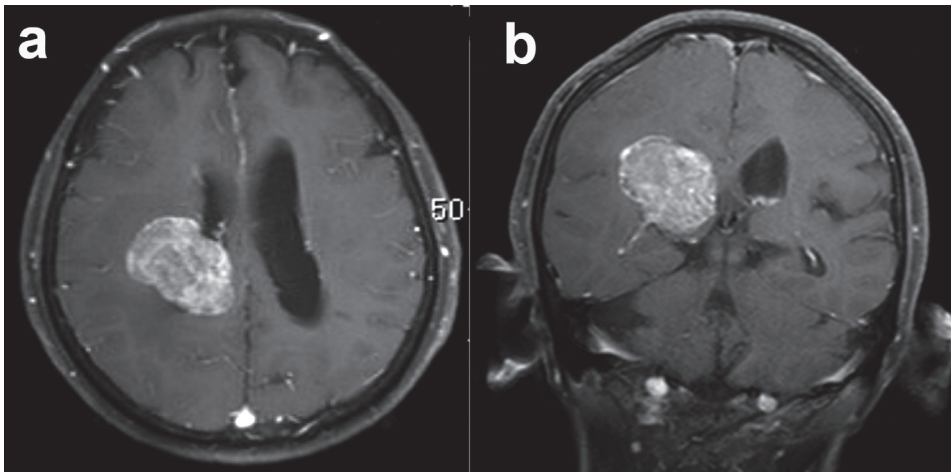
(a) Axial and (b) coronal view of gadolinium-enhanced magnetic resonance imaging (MRI) demonstrating a well-demarcated tumor within the lateral ventricle.
